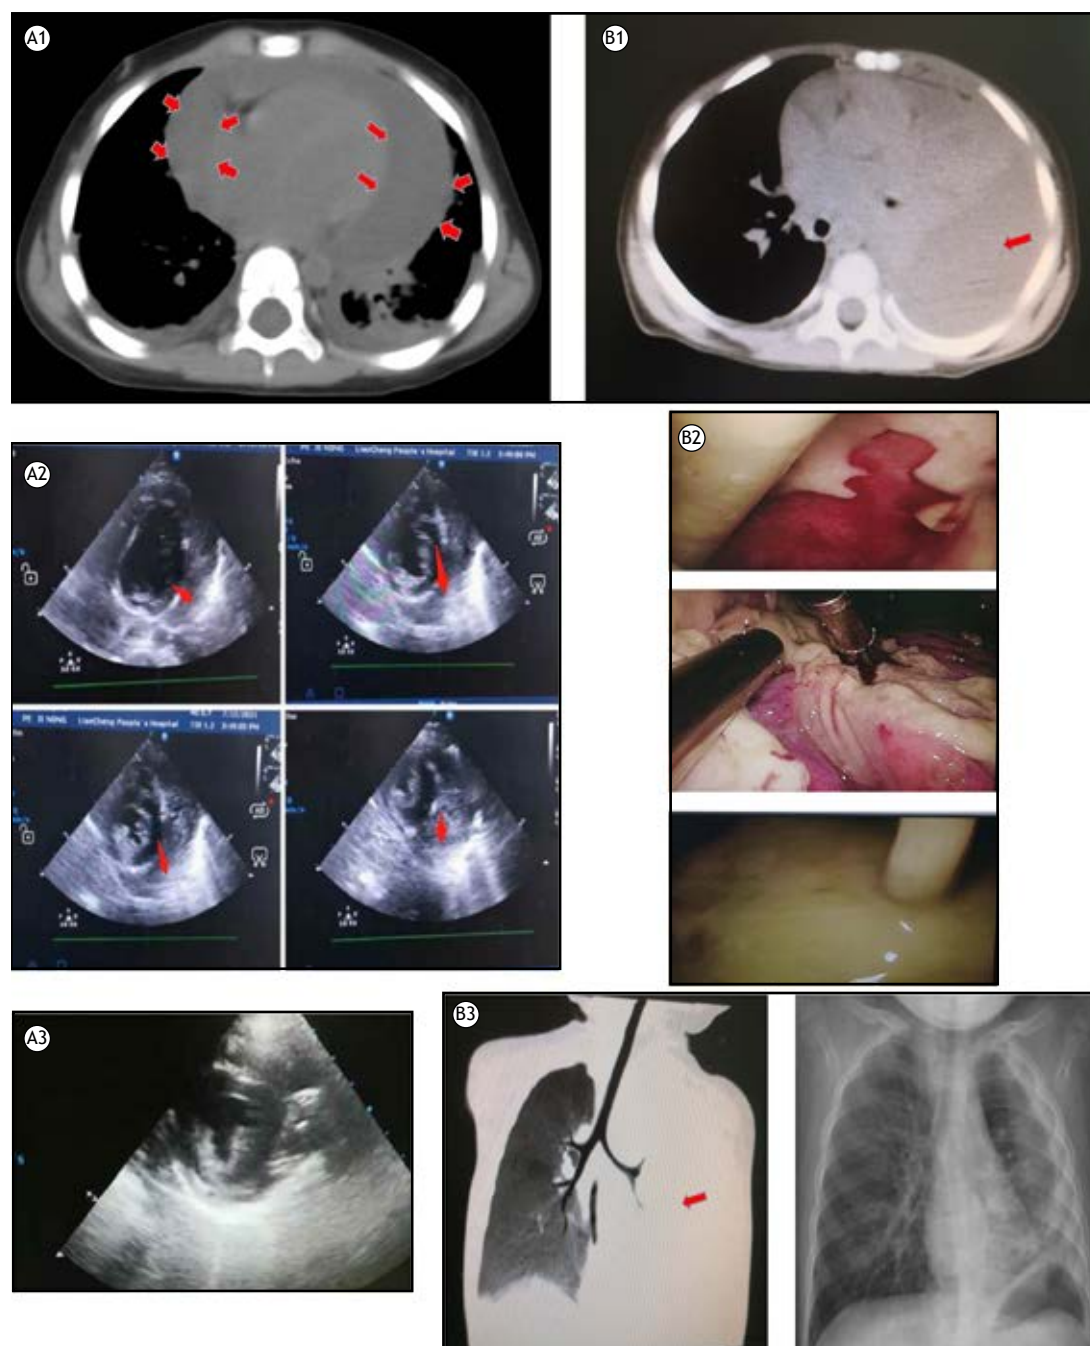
In A1, a chest CT scan showed the presence of pneumonia, bilateral pleural effusions, and substantial pericardial effusion (red arrow). In A2, cardiac ultrasound showed cellulose-like material in the pericardium. In A3, an echocardiography image showing the negligible amount of pericardial effusion remaining. In B1, a CT scan showing consolidation in the left lung, atelectasis areas, and pleural effusion (red arrow); In B2, the pleural cavity's fibrous purulent material and pus could be cleared under direct vision. In B3, the left picture was a CT scan at admission, and the right picture was a CT scan conducted four months later confirming the child's complete recovery.
